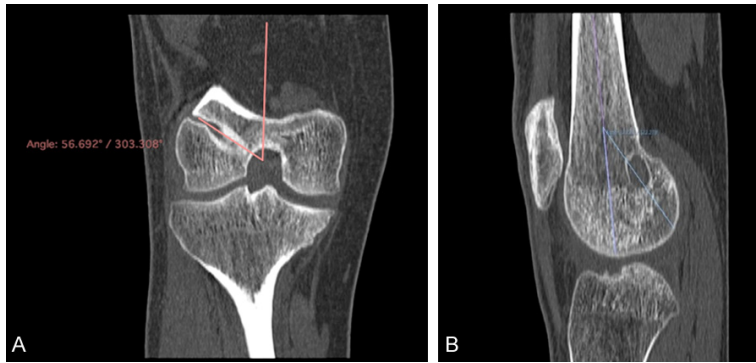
Coronal and sagittal femoral tunnel angle. A. A line parallel to the axis of femoral tunnel and a line bisecting the femoral shaft were used to calculate the coronal inclination of the femoral tunnel in computed tomography scan. B. The sagittal inclination of femoral tunnel was calculated relative to the line bisecting the femoral shaft in the lateral views of computer tomography scan.
